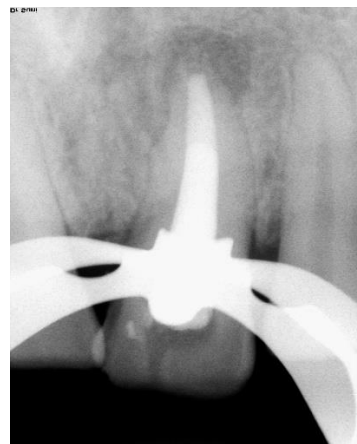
Post-operative radiograph showing apical plug of MTA and obturation
